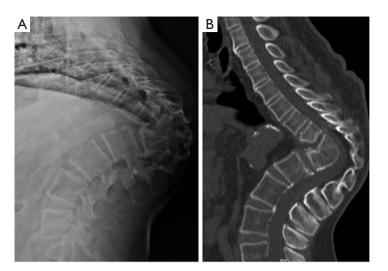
Preoperative X-ray and CT. (A) X-ray lateral view shows post tuberculous kyphotic deformity of 110 degrees; (B) sagittal CT section shows healed tuberculosis with kyphotic deformity. CT, computed tomography.
